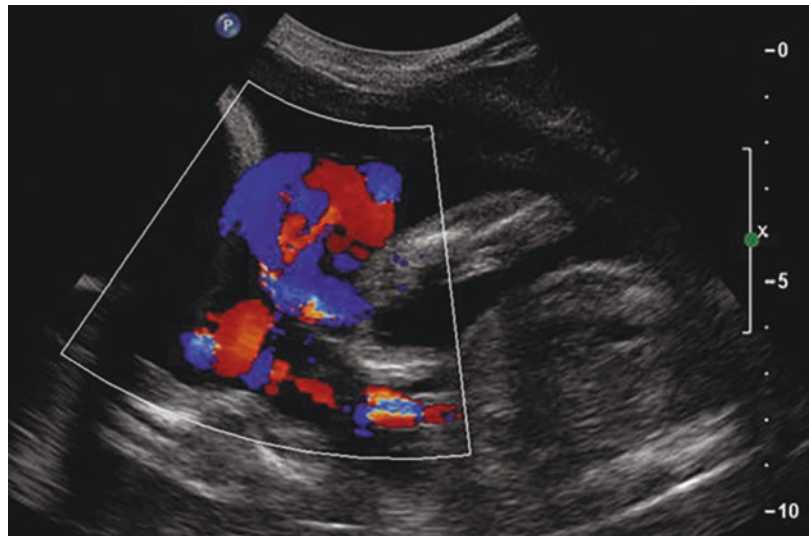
Cord entanglement in monoamniotic twins. In this color Doppler image, a mass containing both cord is appreciated. The gestation is not in the first trimester but in the early second trimester
